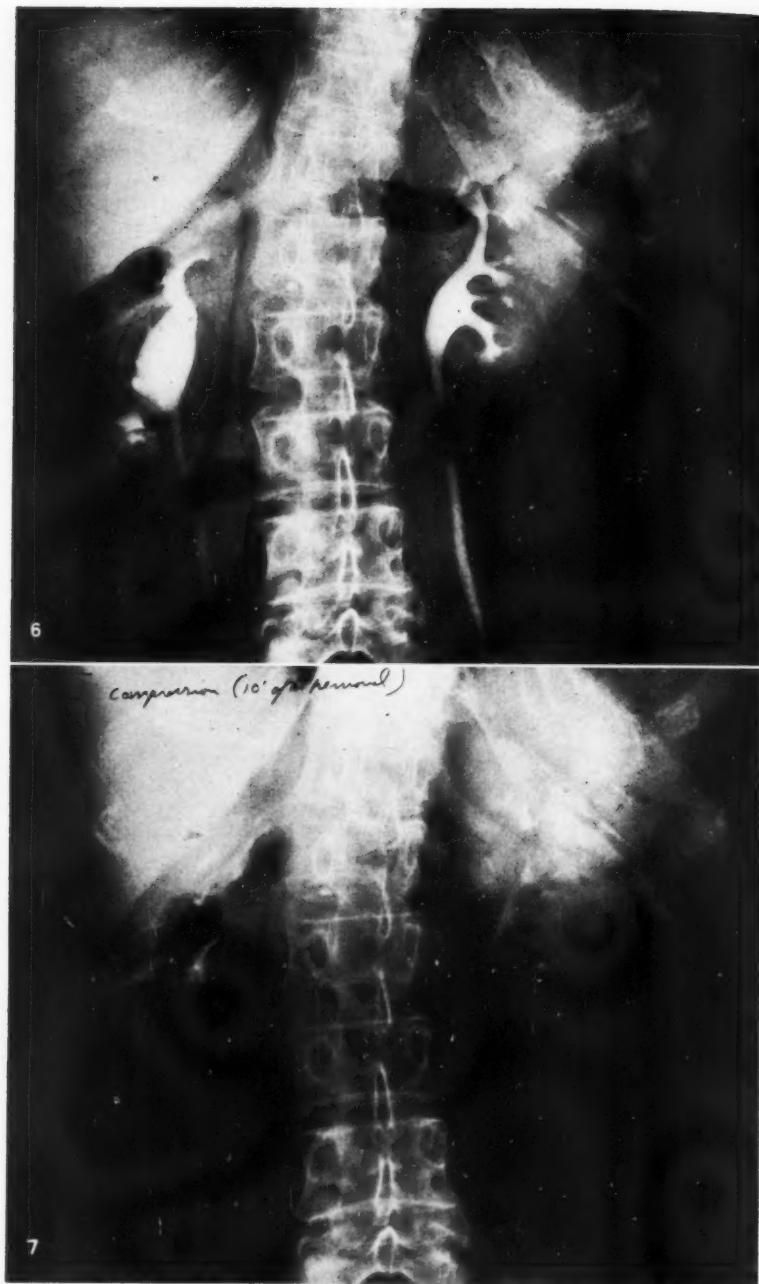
Case II. Roentgenogram following intravenous injection of 50 per cent Hypaque, demonstrating normal appearance of the pelvis and calyceal system, but with the opaque medium outlining dilated structures in the pyramidal portions of some of the calyces, particularly the lower pole of the right kidney, representing dilated tubules in these areas.
